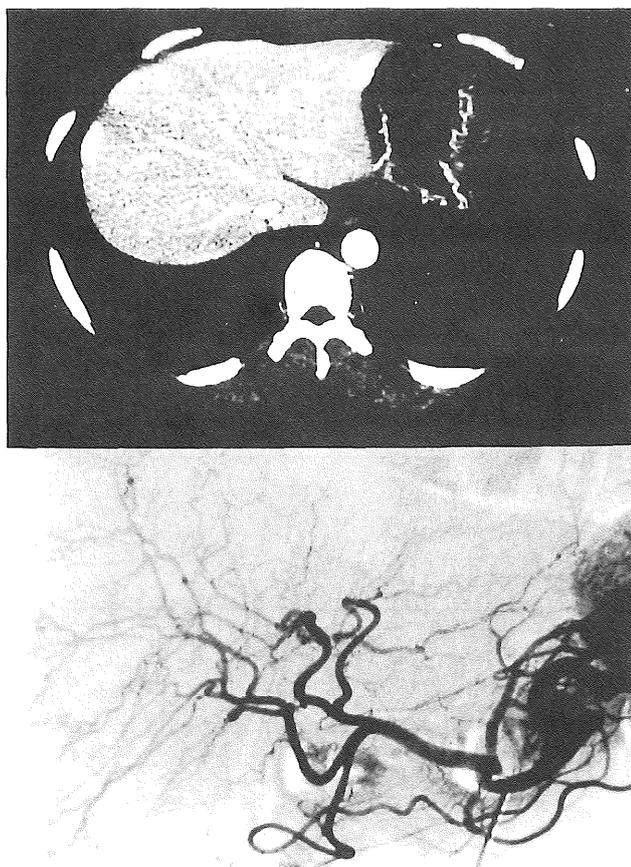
Preoperative CT scan of the recipient
